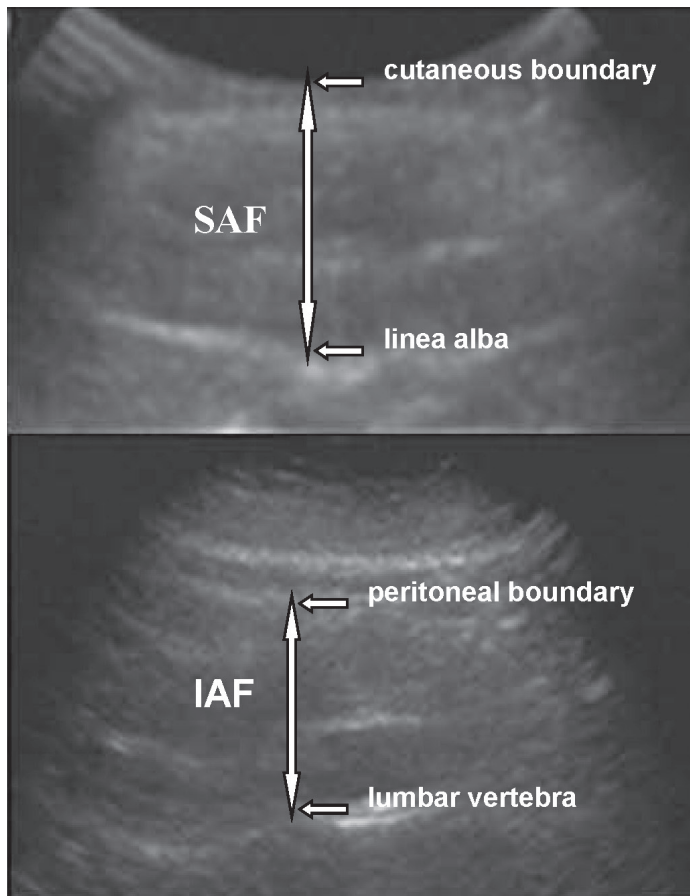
Example of an ultrasound (US) showing the intra-abdominal fat (IAF) and the subcutaneous abdominal fat (SAF) measurements.
